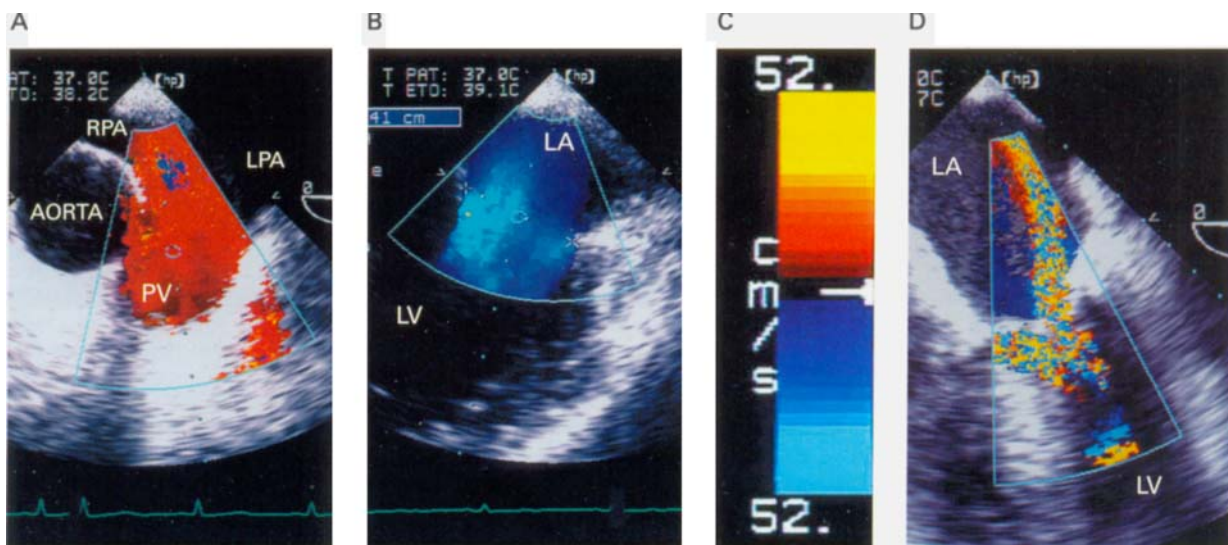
Colour Doppler flow. (A) Blood flow in pulmonary artery: it is depicted in red since it flows toward the transducer. (B) Diastolic flow through the mitral valve: it appears in blue because it is moving away from the transducer. (C) Colour bar: in enhanced colour maps the red gradually changes to yellow and the blue to an intense luminous shade as the velocity increases; this display is advantageous in operating rooms because it increases the contrast with the surrounding light. (D) Mitral regurgitation: turbulent flow is represented by a mosaic of disorganised multicoloured dots. LA = left atrium, LV = left ventricle, LPA = left pulmonary artery, PV = pulmonary valve, RPA = right pulmonary artery. (Adapted from Chassot.³⁸)
